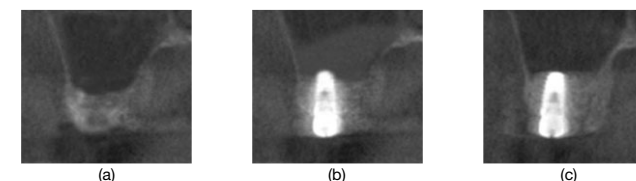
Staged CBCT image (coronal view)
